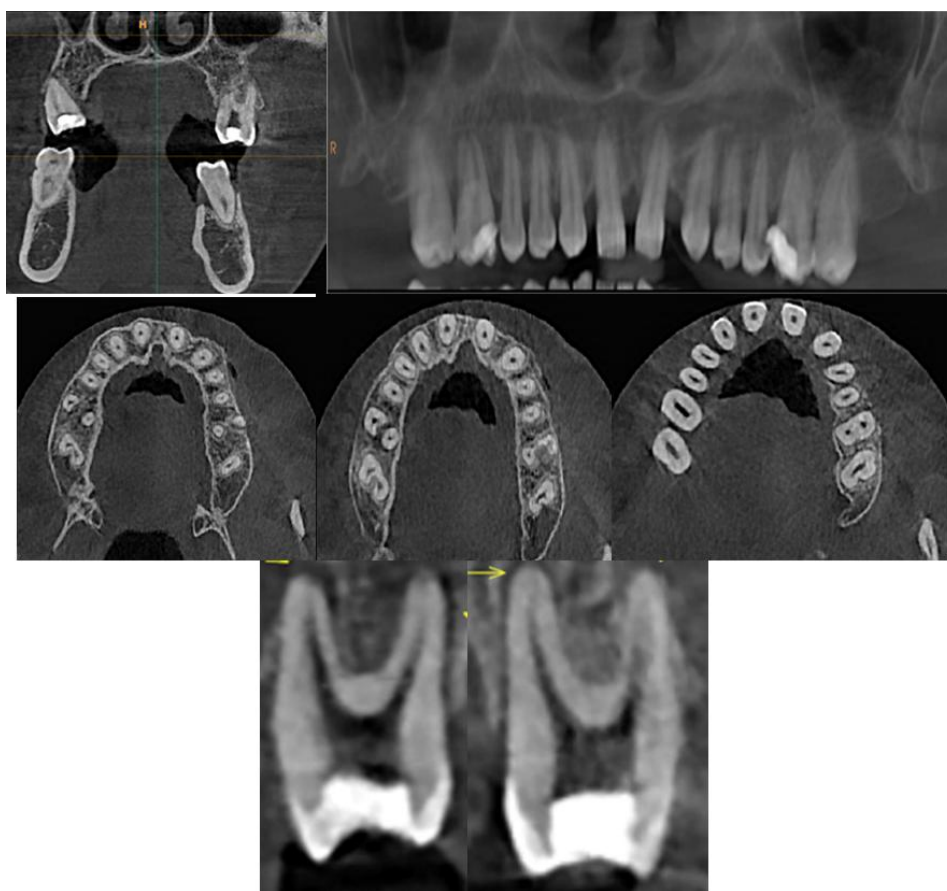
Cone-beam computed tomography coronal section; axial section at cervical third, middle third level, apical third level and sagittal section
